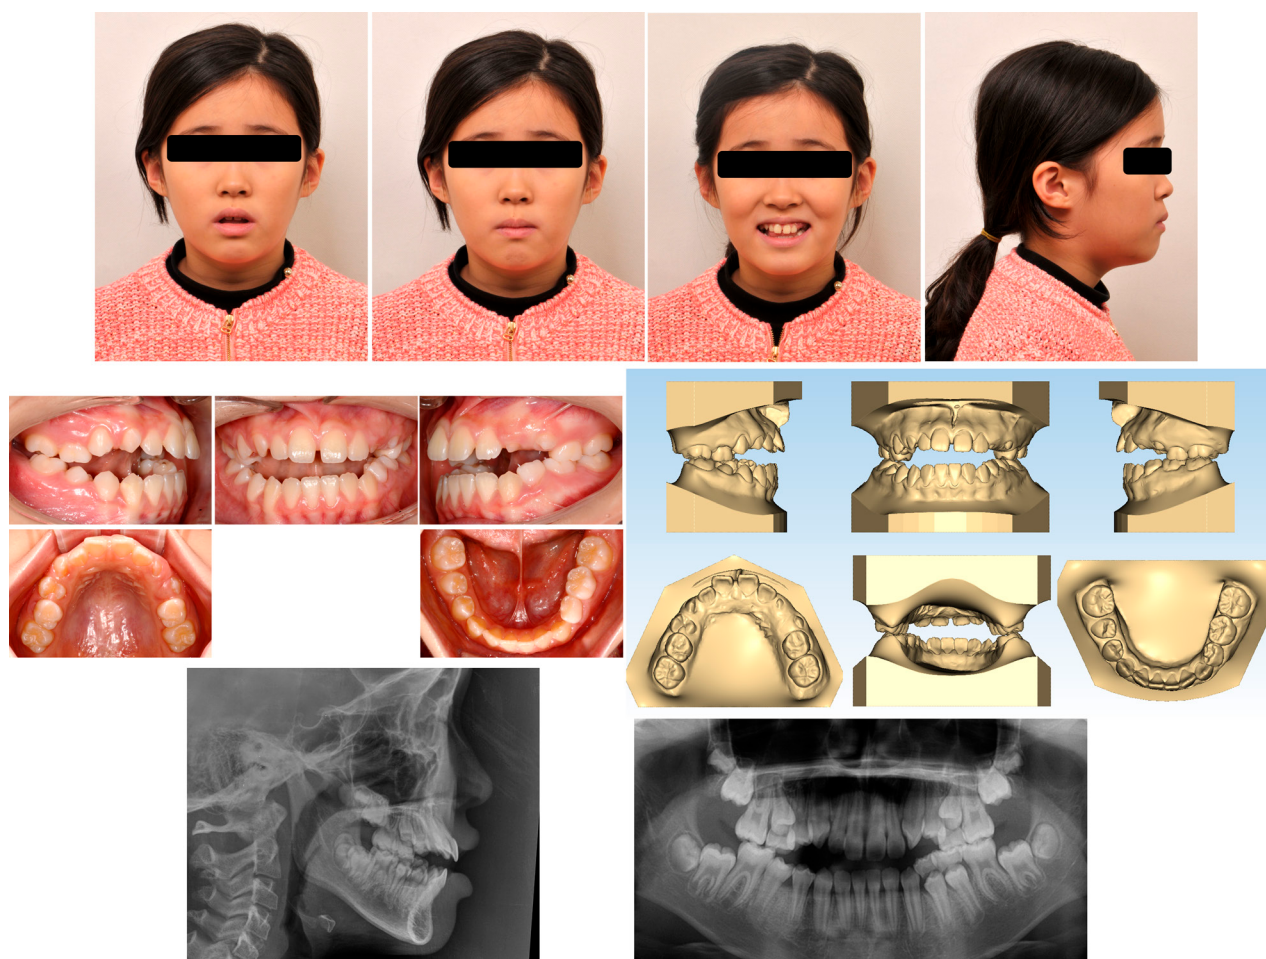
Pretreatment records, including extraoral and intraoral photographs, cephalogram, panoramic radiograph, and three-dimensional virtual model.
